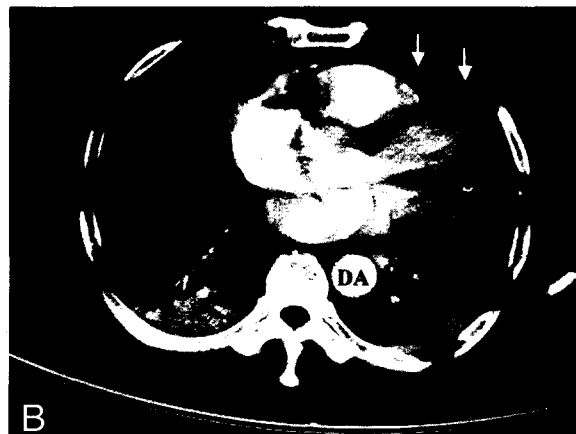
A, B: CT scans show intimal flaps (arrow head) in ascending aorta, hemopericardium (white arrow), and hemothorax (black arrow). AA = ascending aorta; DA = descending aorta.
